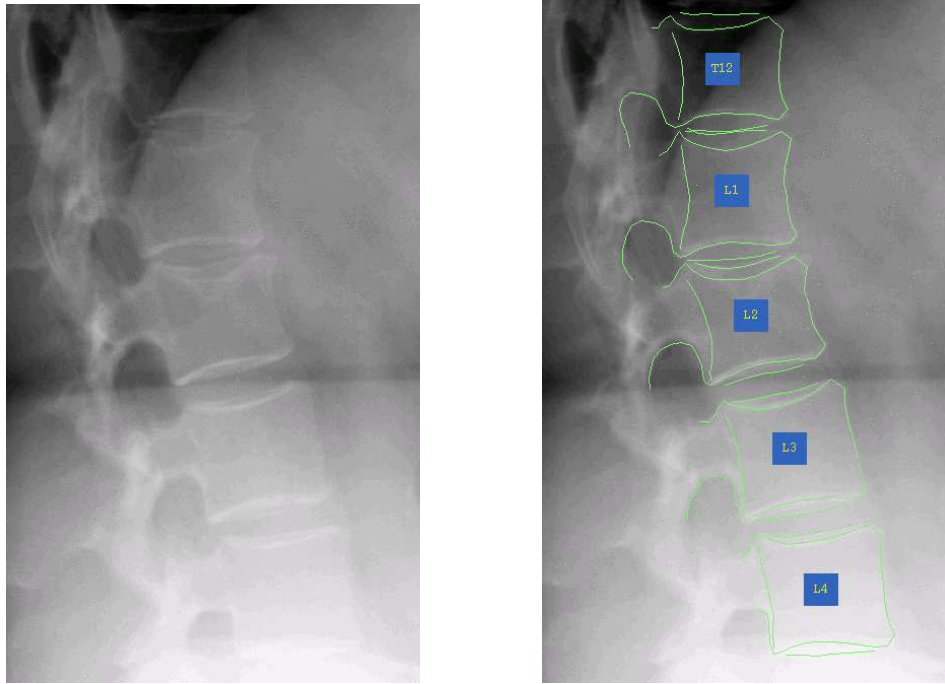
Lumbar radiograph. a) shows the raw image (contrast enhanced); b) shows the automatically located vertebral contours superimposed.
